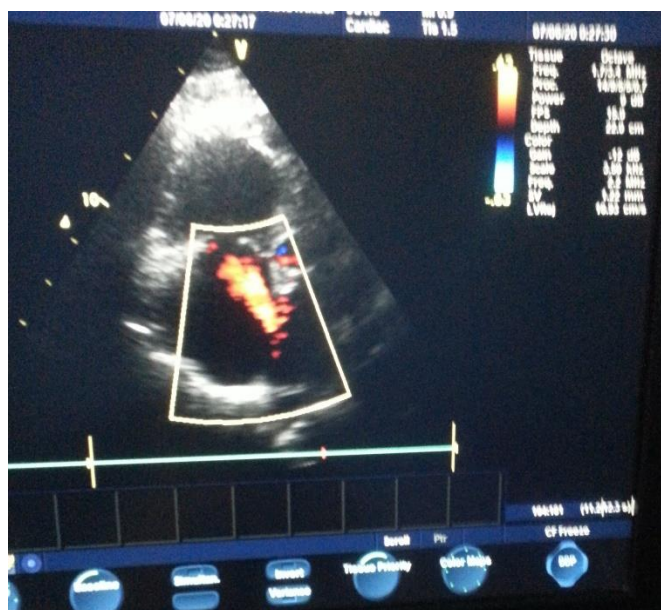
Secundum atrial septal defect by transthoracic echocardiography window
